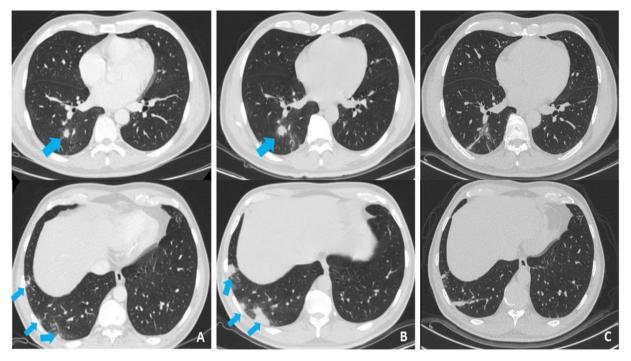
Non-contrast chest CT: (A) Appearance of fast-growing nodules in the right lung parenchyma at the end of the first course of chemotherapy with FLOT. (B) Control CT one week later. (C) Residual scarring lesions, after 4 months of antifungal treatment.
